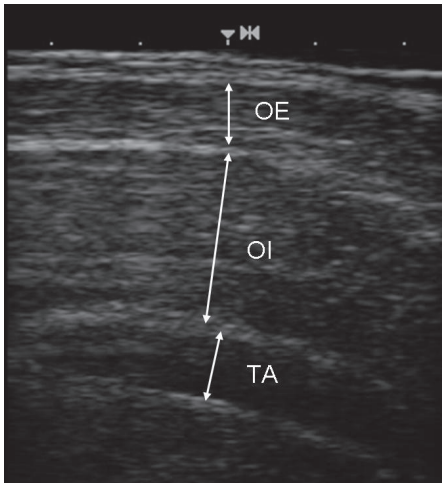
Measurement methodology for ultrasound imaging of the abdominal muscles. TA, transversus abdominis; OI, obliquus internus; OE, obliquus externus.
